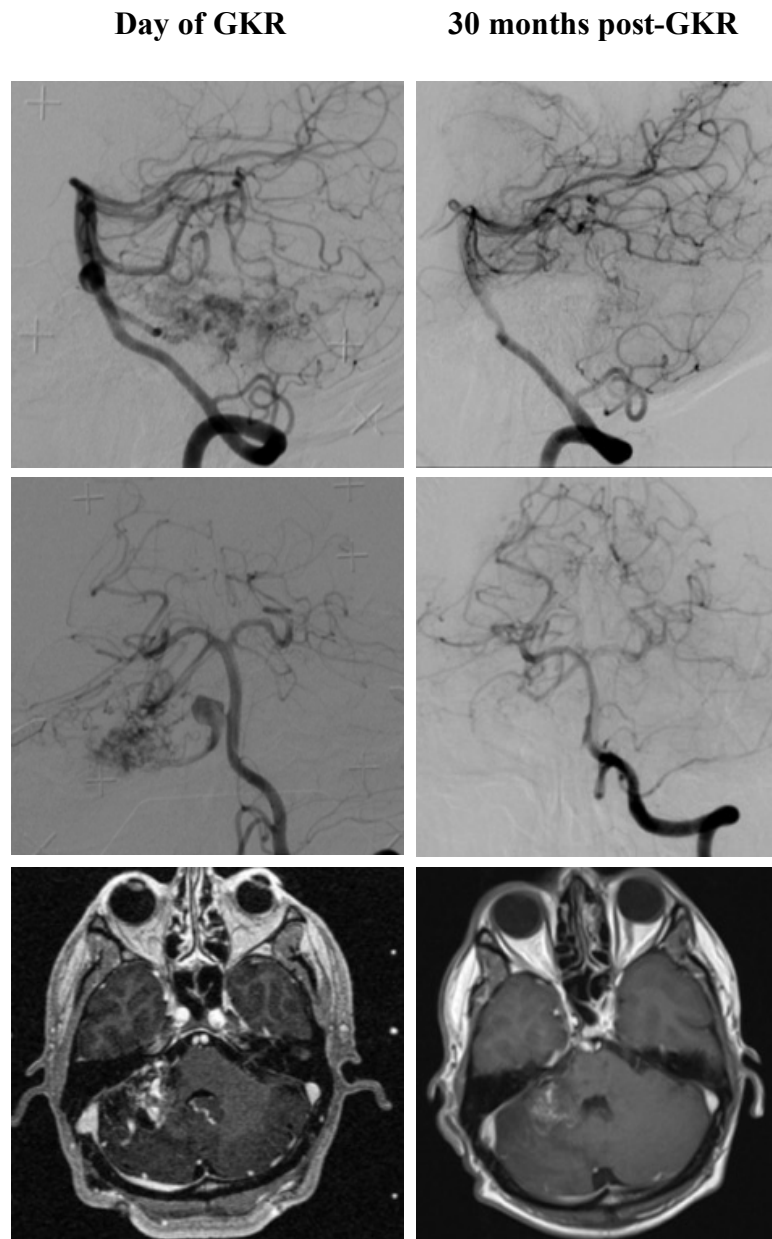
Right cerebellar AVM treated with GKR. Left: DSA and MRI (bottom) performed on the day of GKR showed a sizeable right side cerebellar AVM which was treated with GKR. Right: MRI scan (bottom) of the same patient 30 months after GKR shows reduction of size of the treated vascular abnormality and DSA (top) confirmed treatment response.
